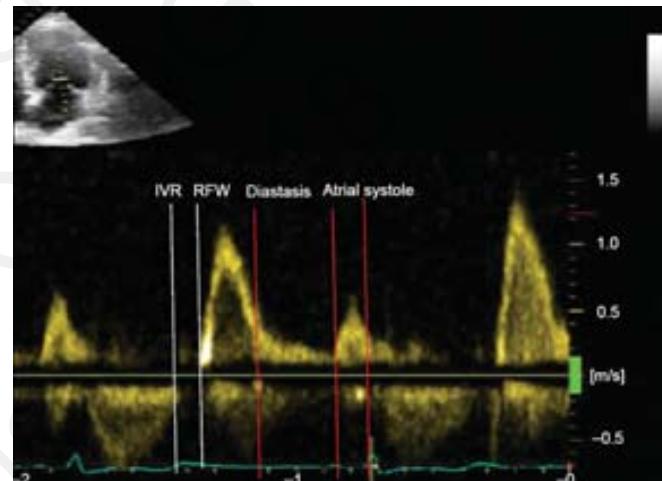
Doppler interrogation with sample volume placed between the left ventricular outflow and the inflow showing all four phases of diastole: (1) IVR—isovolumic relaxation, (2) RF—rapid filling, (3) diastasis—slow filling, and (4) AC—late filling due to atrial systole.
